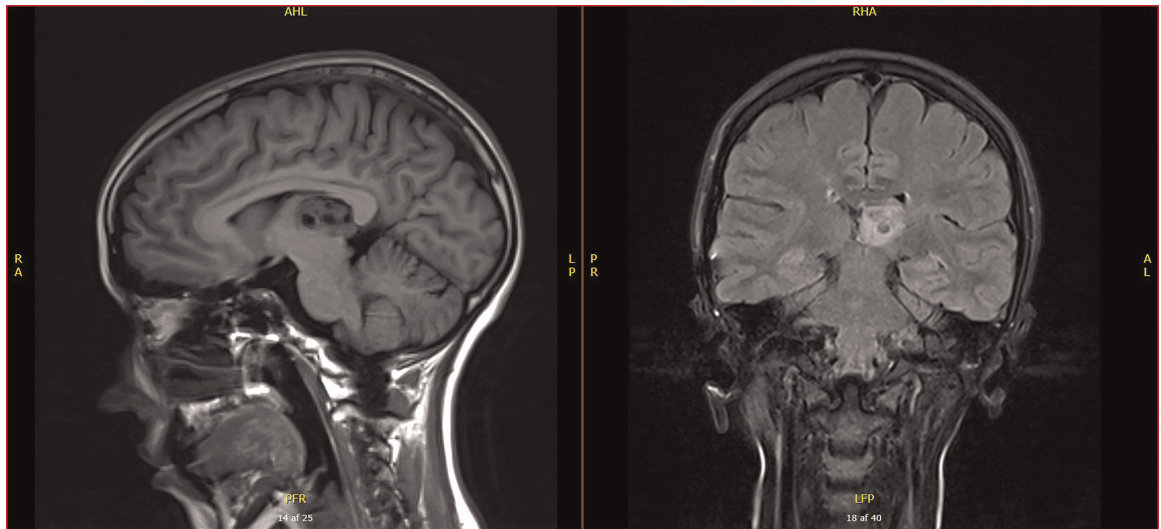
Latest magnetic resonance imaging of the high-grade astrocytoma with piloid features, showing stable tumor size.
